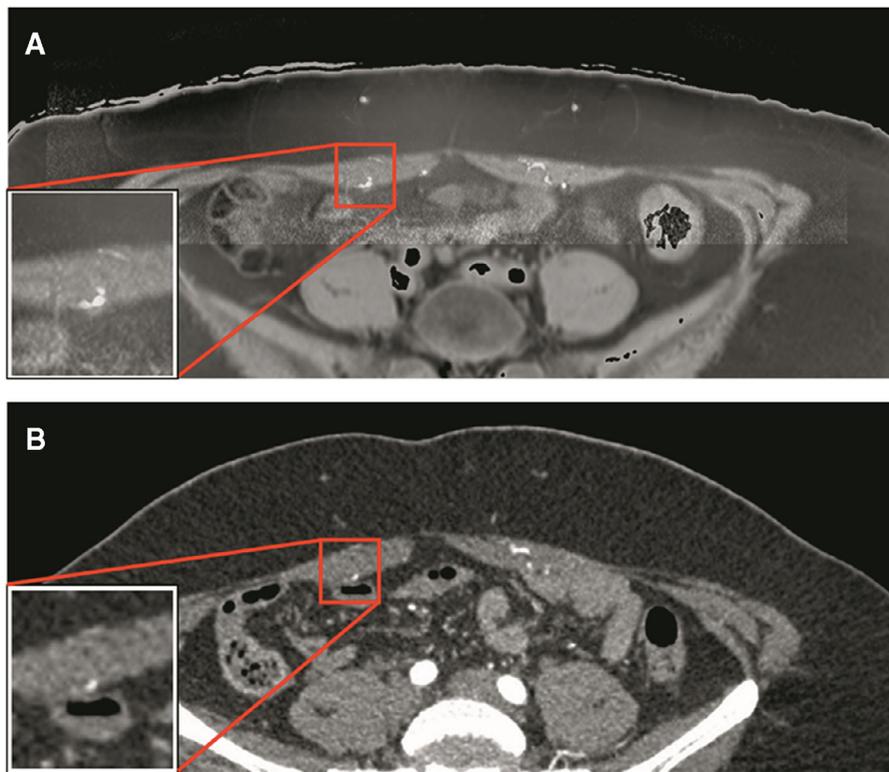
Deep inferior epigastric artery perforator flap pPCA and CTA data (both 1.5-mm-thickness) from a 50-year-old female patient with BMI 31.6. The pPCA images (A) demonstrate a higher degree of contrast, and less noise than CTA images of the same slice thickness (B). Inlets in (A) and (B) demonstrate that pPCA visualizes not only perforator arteries, but also perforator veins that are invisible in CTA images.
